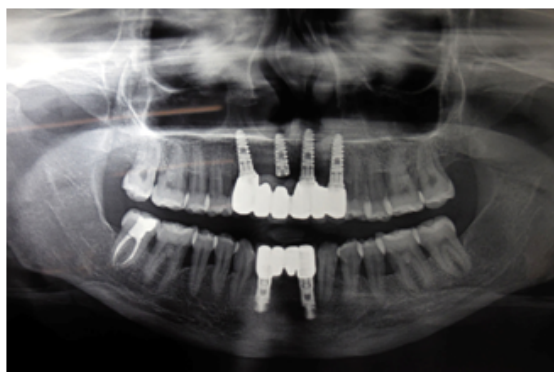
Orthopantomogram showing post implant restoration with maxillary and mandibular anteriors.
